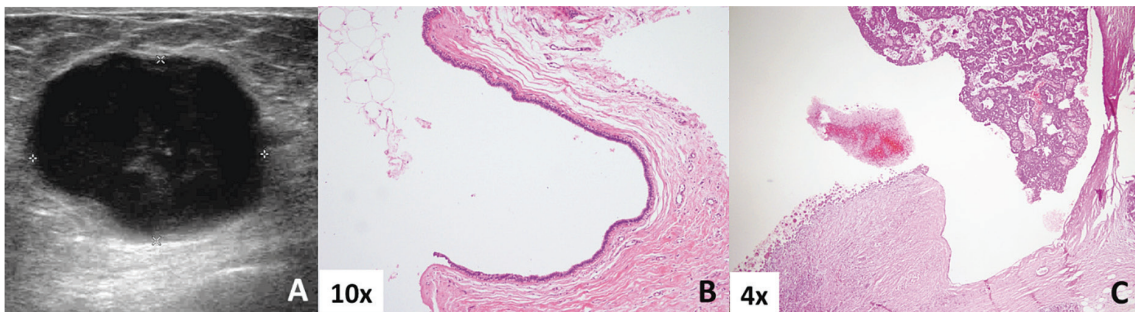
False negative case from papillary lesion, A, Ultrasonography showed solid cystic mass. B, CNB; Chronic inflammation with dilated mammary duct. C, Open biopsy; Encapsulated papillary carcinoma
